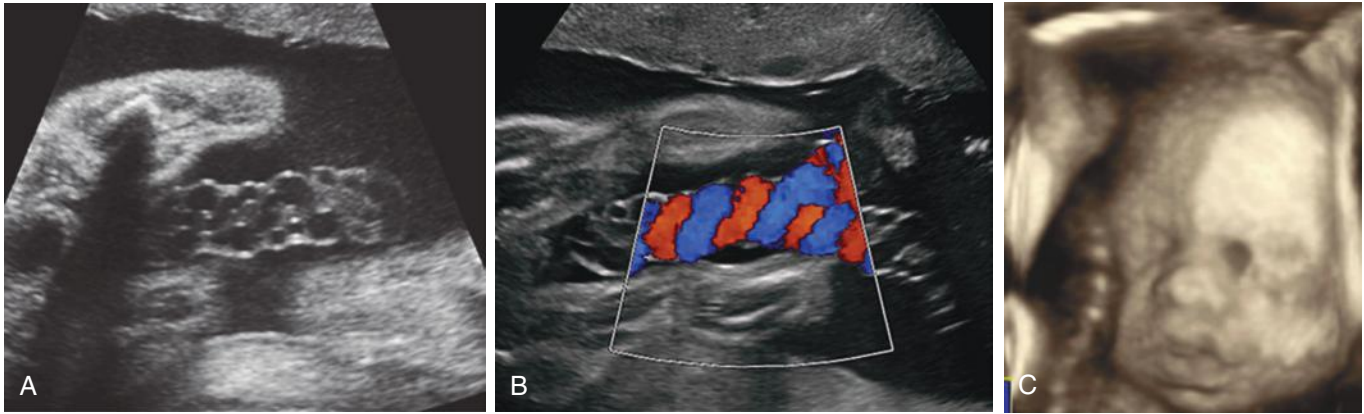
Hypercoiled umbilical cord. A, Hypercoiling of the umbilical cord vessels was incidentally noted during a routine second-trimester sonogram. B, Color Doppler imaging depicts the coiled loops of cord. C, Three-dimensional sonography shows the coiling of this umbilical cord in the third trimester.
